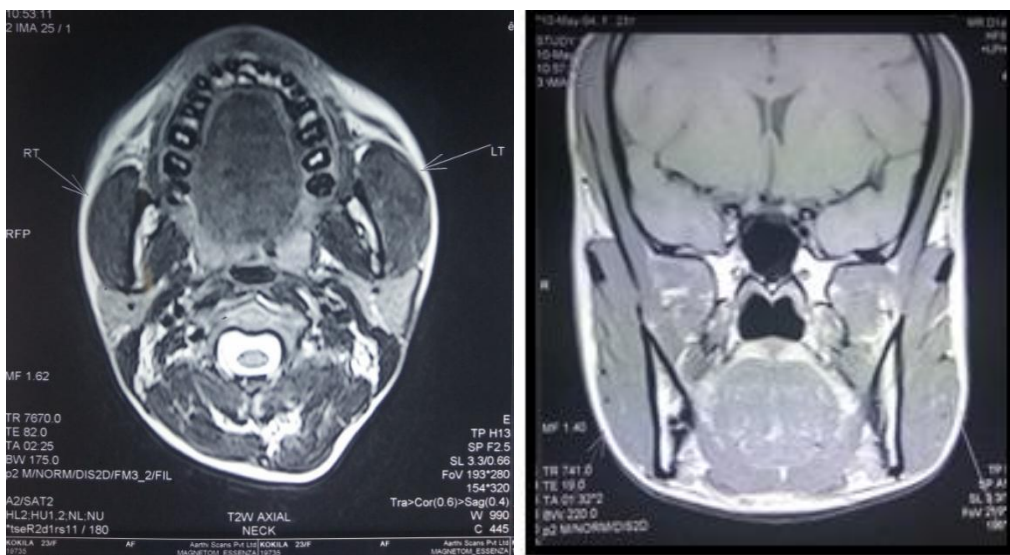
Axial and coronal T2-weighted magnetic resonance image showed nonenhancing hypertrophy of the left masseter compared to the right side.
